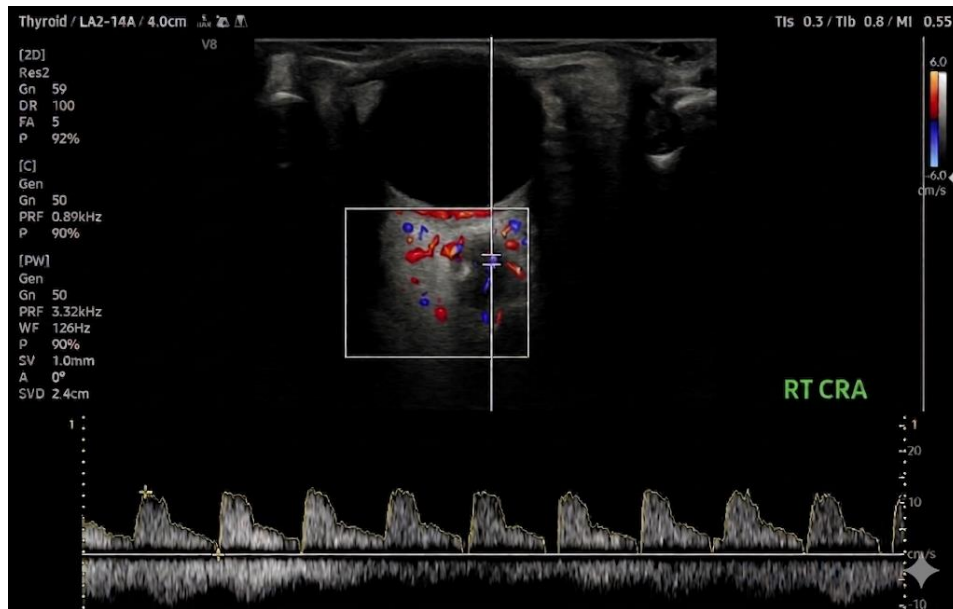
Colour Doppler of Normal Central Retinal Artery
